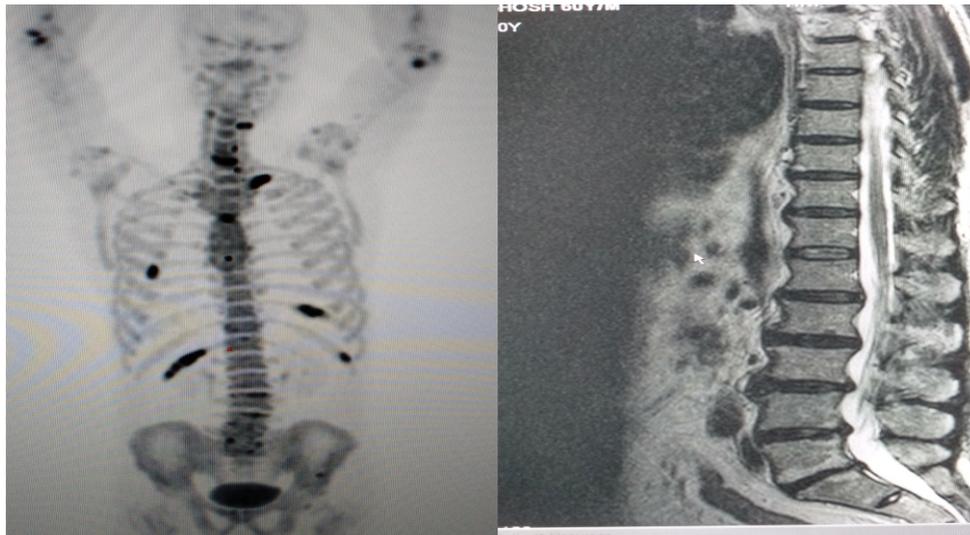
Case of Ca Lung. PET CT Scan shows increased uptake in C3, C6, D1 and D7. MRI sequences showed only degenerative changes.
